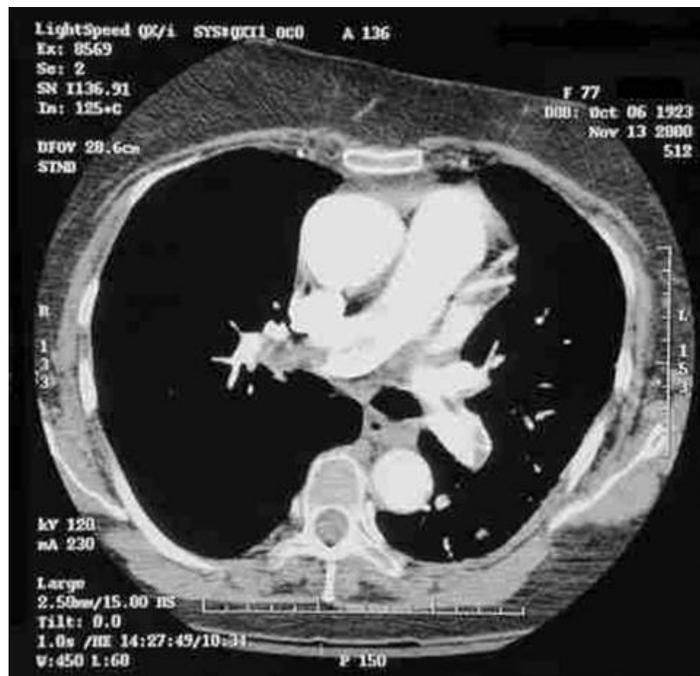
A spiral CT scan shows thrombus in bilateral main pulmonary arteries
